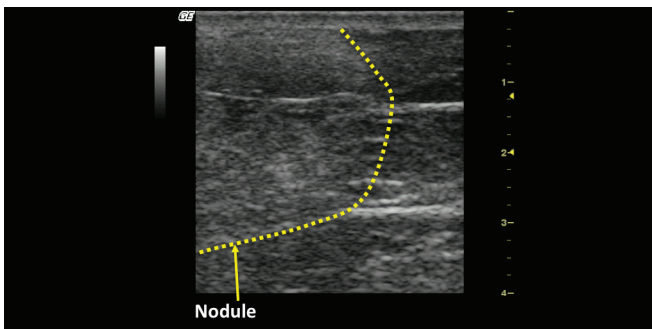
Shows ultrasound of nodule formation post 30-minute treatment.
